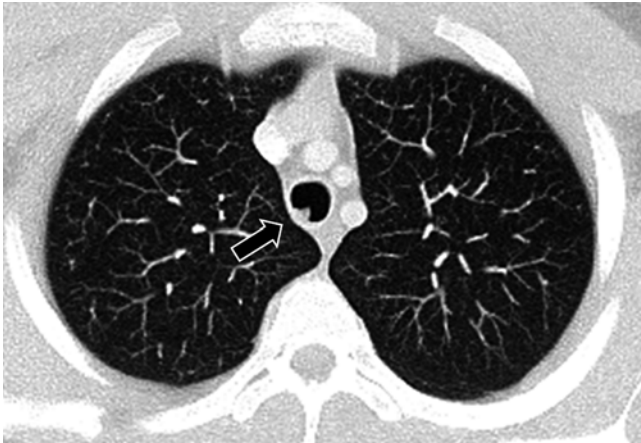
Recurrent respiratory papillomatosis in a 17-year-old boy with known diagnosis since the age of 1.5 years. Axial CT image shows an intratracheal soft tissue lesion (*arrow*) (Case courtesy of Hedieh K. Eslamy, MD, Department of Radiology, Lucile Packard Children's Hospital, Stanford, CA)
